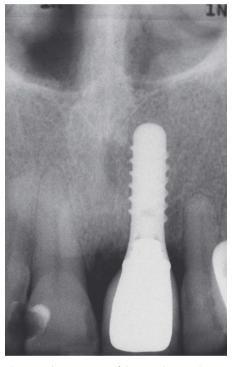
Shows an X-ray of the seated restoration: the metal coping supports the ceramic so that a homogeneous layer thickness of max 1-1.5 mm is possible
